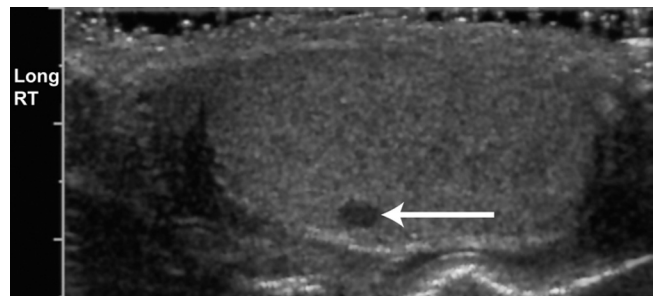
44-year-old male with Leydig-cell tumor. Sagittal sonogram of the right testis shows a 3-mm hypoechoic nodule (arrow).
